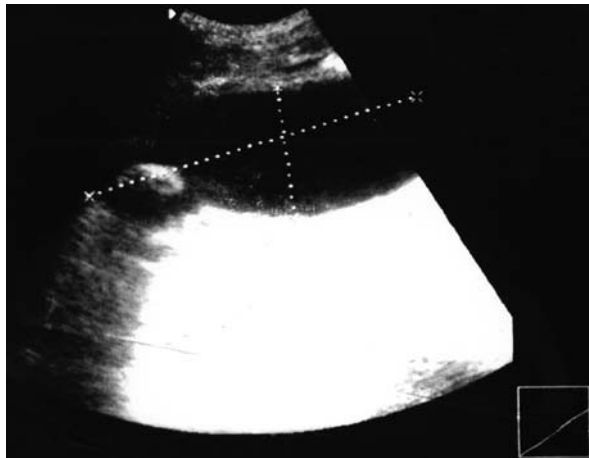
Abdominal ultrasonography showing enlarged gallbladder with thickened wall and stone
